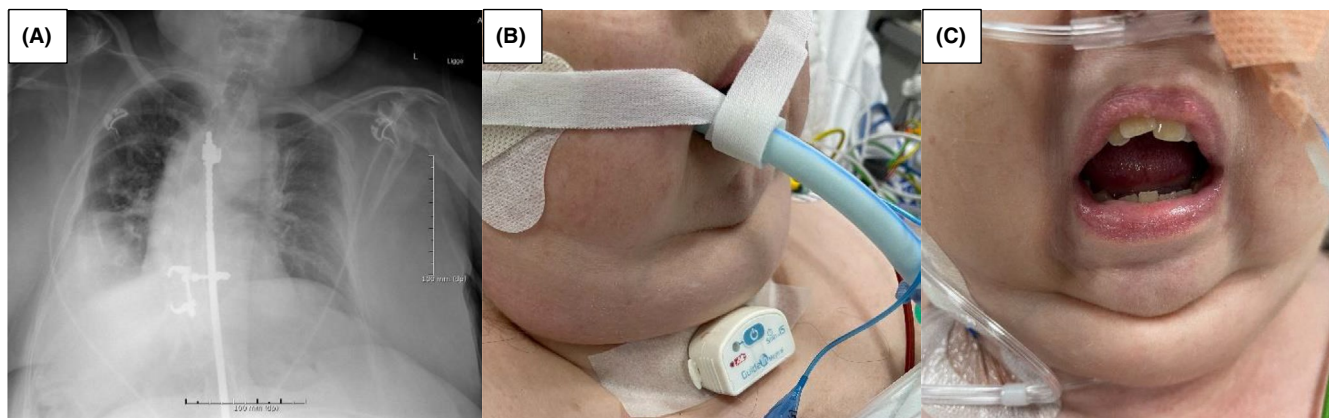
Patient's chest X-ray before intubation showing bilateral pneumonia, atelectasis, and severe scoliosis with a Harrington rod (A). The patient after intubation, Infrared Red Intubation System placed on outer trachea (B). The patient after extubation, demonstrating maximal mouth opening of 13 mm (C)
